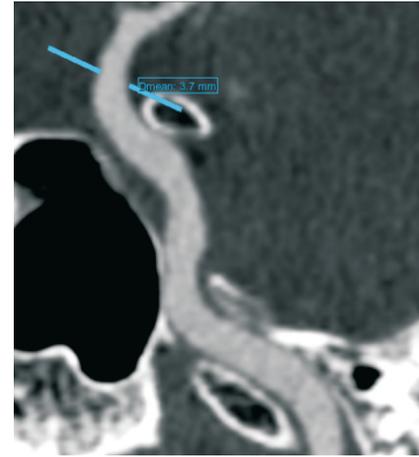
Head-and-neck CTA inspection showed the diameter of ICAS.
